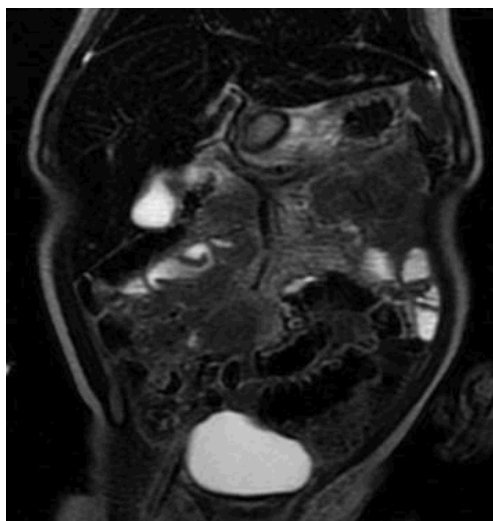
An additional abdominal ultrasound control showed a normal pylorus and was completed by an MRI-scan which confirmed the presence of retro-pyloric cystic lesion.
